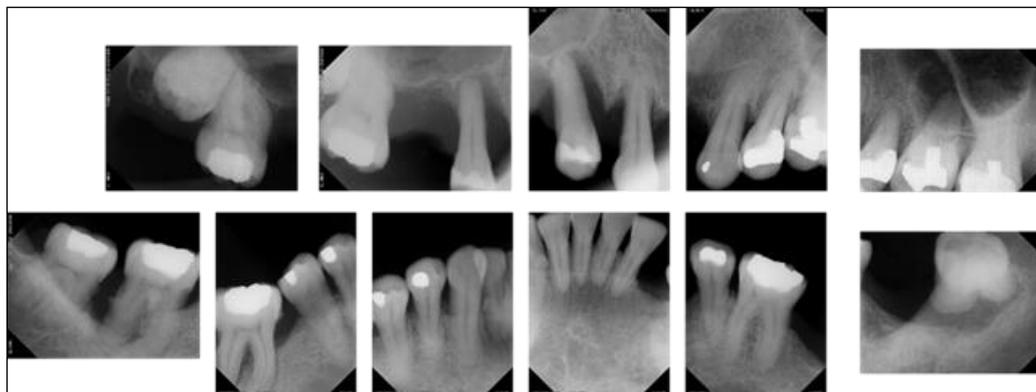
Radiographic series.
